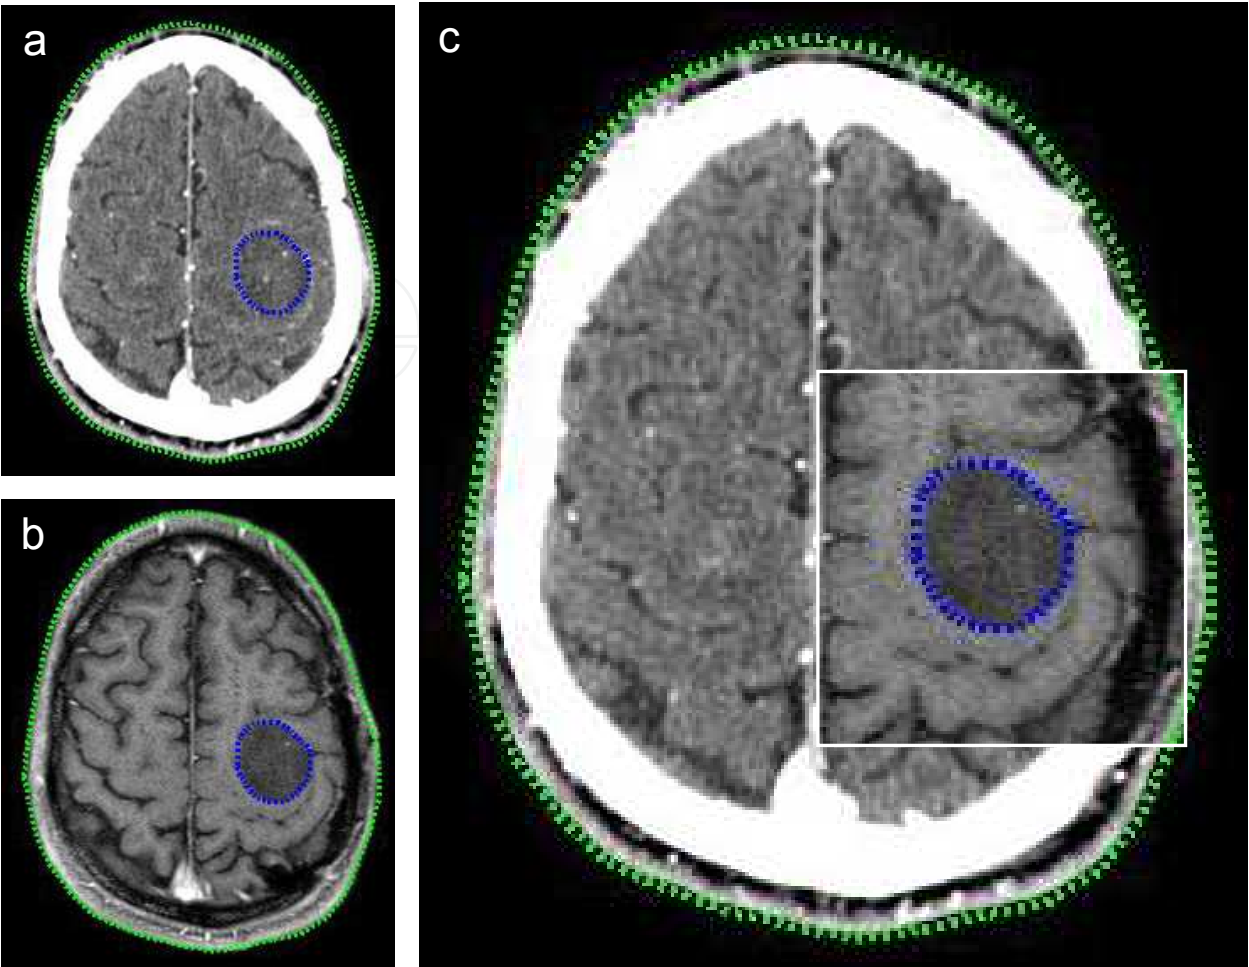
Image fusion of CT and MRI scans. a) CT image; b) MRI image. c) The blue dotted line represents the manually outlined tumor margin.
